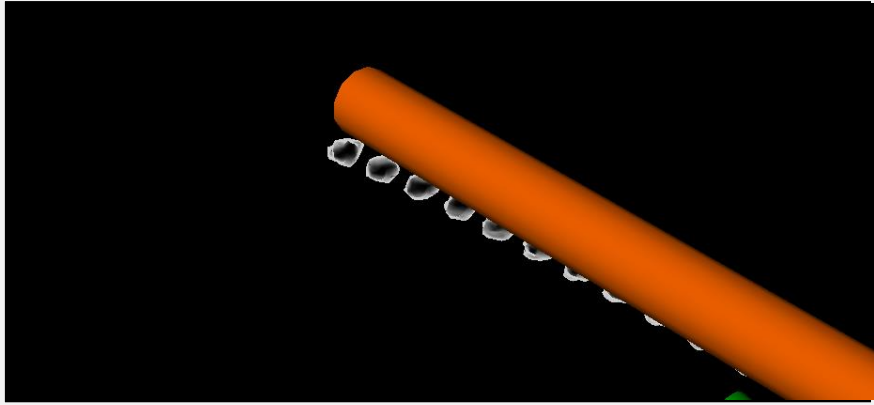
Validation of plan with postoperative CT. Upon registration, the user can compare the surgical plan referred to MR2c with the real outcome (using our segmentation method on the postoperative CT).
